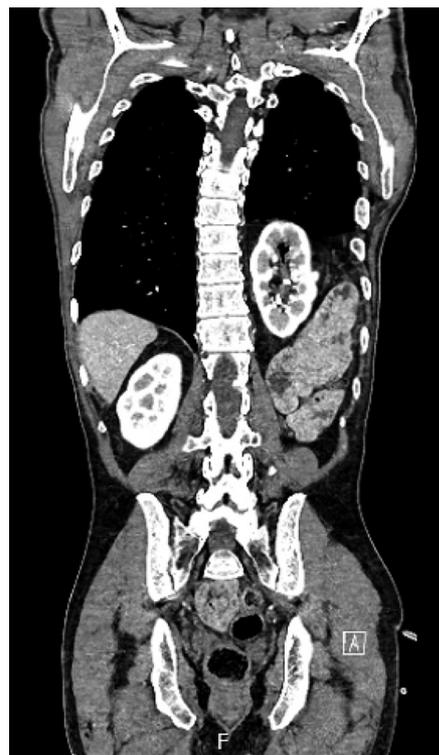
Coronal CT image after percutaneous nephrostomy placement prior to hernia repair and nephropexy.
